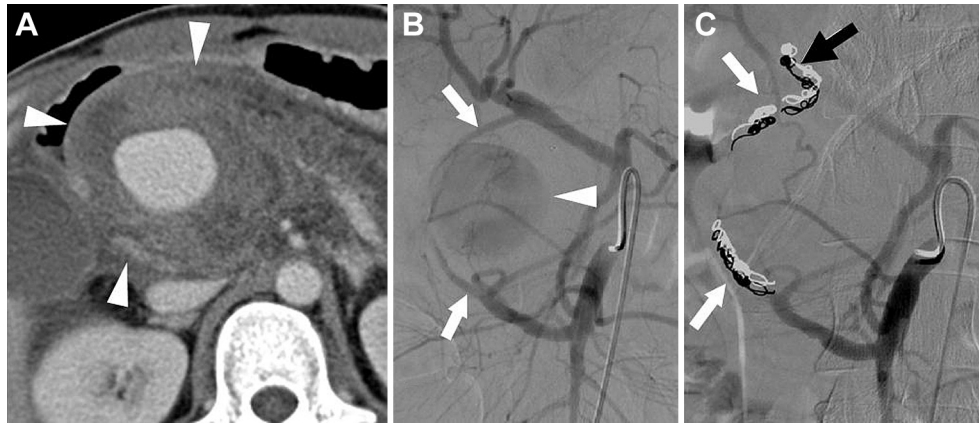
A 29-year-old male with chronic pancreatitis presented with hematemesis. (A) Contrast-enhanced computed tomography shows a large pseudoaneurysm with peripheral thrombus in the pancreatic head region (arrowheads). (B) Selective digital subtraction angiography shows the pseudoaneurysm (arrowhead) arising from the inferior pancreaticoduodenal artery (IPDA) with an additional supply from the GDA (arrows). (C) Feeders from both arteries accessed through the IPDA and coil-embolized (arrows). Complete isolation of the pseudoaneurysm achieved. Note prolapse of one of the coils into proper hepatic artery (C, black arrow); however, the artery is patent.
